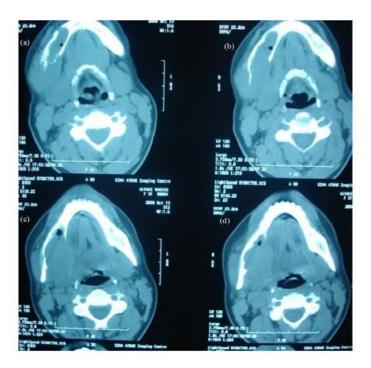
a, b, c and d axial CT scan of skull without contrast media showed soft tissue mass in the right side of the mandibular body associated with bone destruction. The lingual bony table was disappeared on the CT
